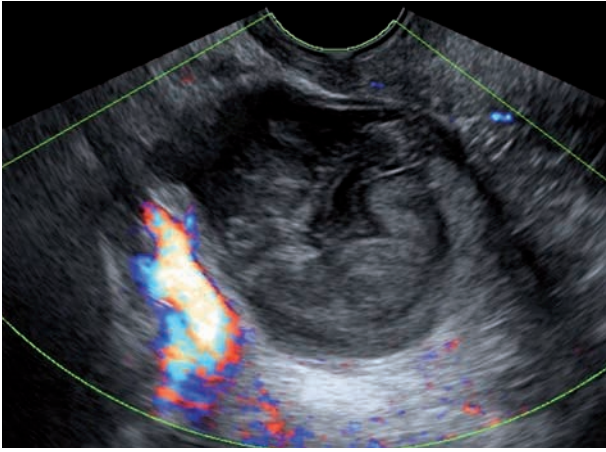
Diagnosis through ultrasonography on routine check-up. Colorscore 1 and Whipped cream characteristic.
